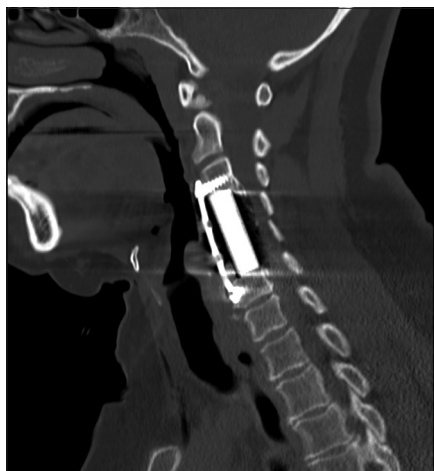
This STAT postoperative parasagittal cervical non-contrast CT study showed the C3-C6 anterior strut graft in place along with the anterior plate. The hypodense mass dorsally extending from the C3-C4 through the C5-C6 levels (i.e. posterior to the graft and anterior to the cord itself) contributed to marked ventral cord compression (i.e., this was due to Duraseal as confirmed on the postoperative MR). Further, the spinal surgeon simply read this STAT postoperative CT study as ruling out an anterior epidural hematoma despite the radiologist's statement that he (the radiologist) could not discern what was going on inside the spinal canal due to marked metallic artifact, thus indicating an additional MR was warranted.
